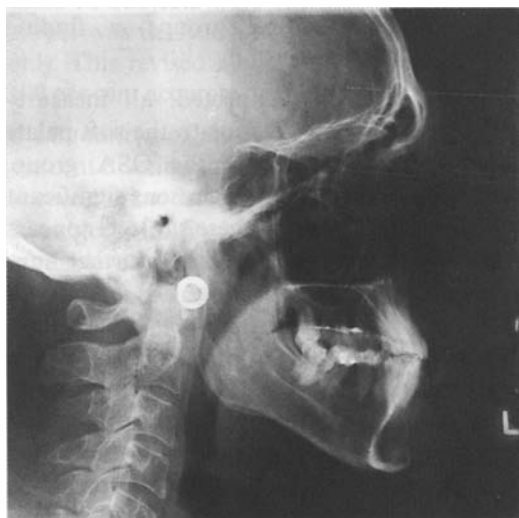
Lateral cephalometric radiograph of a subject with OSA. Vertical and antero-posterior skeletal relationships appear normal but the soft palate is enlarged with consequent reduction in the post-palatal airway, particularly at its narrowest point.Figure 5 Lateral cephalometric radiograph of a control subject. Skeletal relationships are essentially normal, the soft palate is smaller than in the previous film and the pharyngeal airway, particularly behind the soft palate, is increased.
